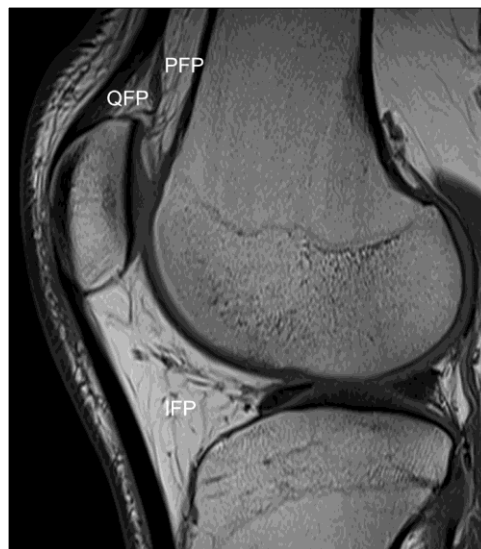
T1-weighted sagittal magnetic resonance image of the knee shows the intracapsular but extrasynovial fat pads –infrapatellar fat pad (IPF), quadriceps fat pad (QFP), pre- femoral fat pad (PFP).
